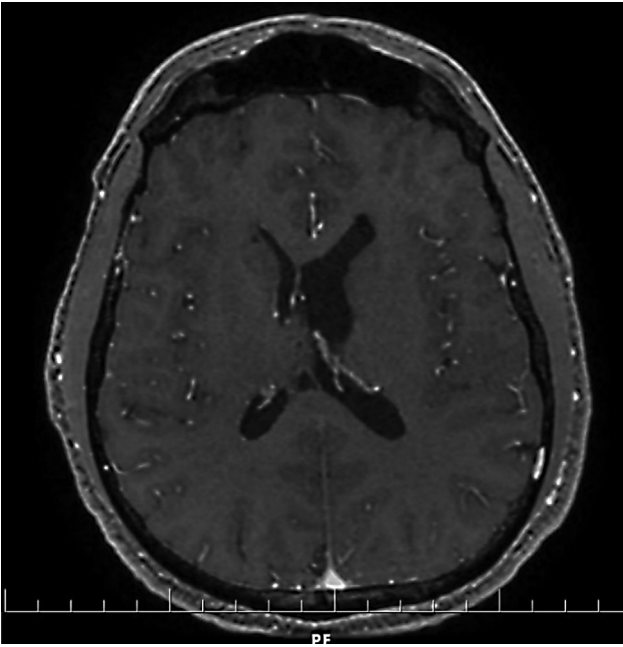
Control of early postoperative contrast-enhanced T1-weighted brain magnetic resonance imaging in the axial plane. The tumor is totally resected, and the right lateral ventricle is moderately dilated.
